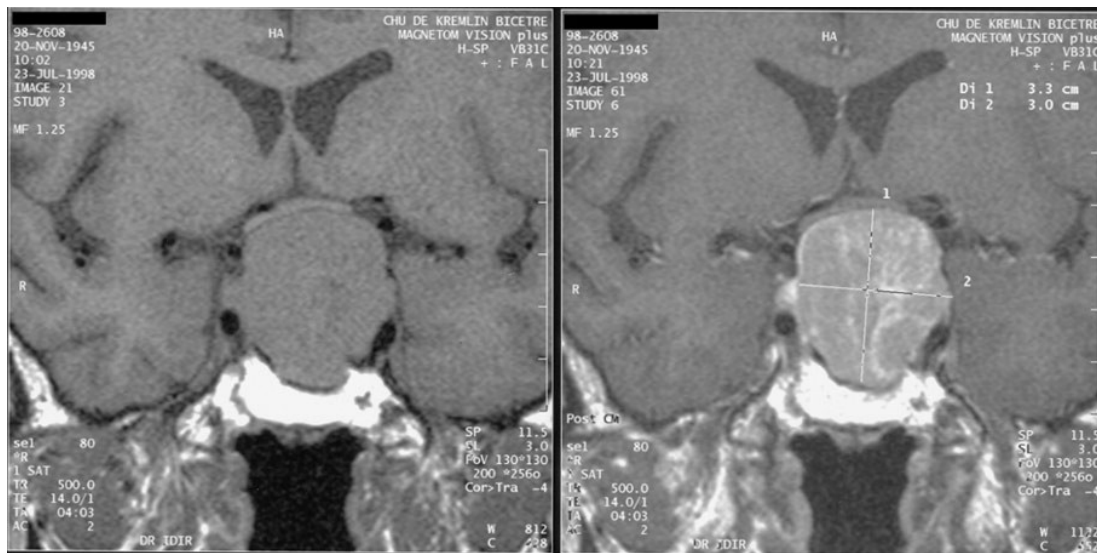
Pituitary tumor in MRI image: Macroadenoma with compression of optic chiasm.
